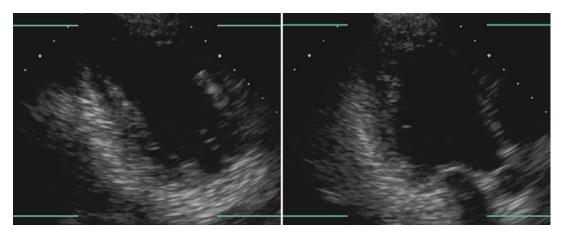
Importance of maintaining the same imaging plane for comparison of pre- and post-stress images. Failure to provide a true apical two chamber view may preclude visualization of the right coronary territory
